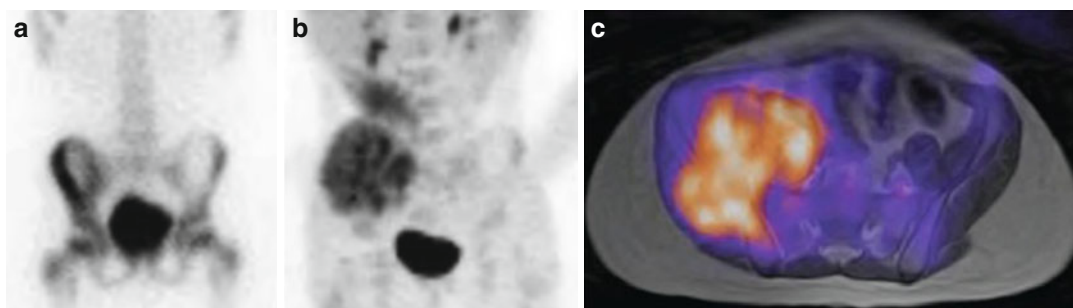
Ewing sarcoma. (a) ^{99m}Tc -MDP bone scan shows increased tracer uptake in the left iliac bone, left acetabulum, and proximal femur. (b) ^{18}F -FDG MIP shows a larger region of increased tracer uptake also involving
